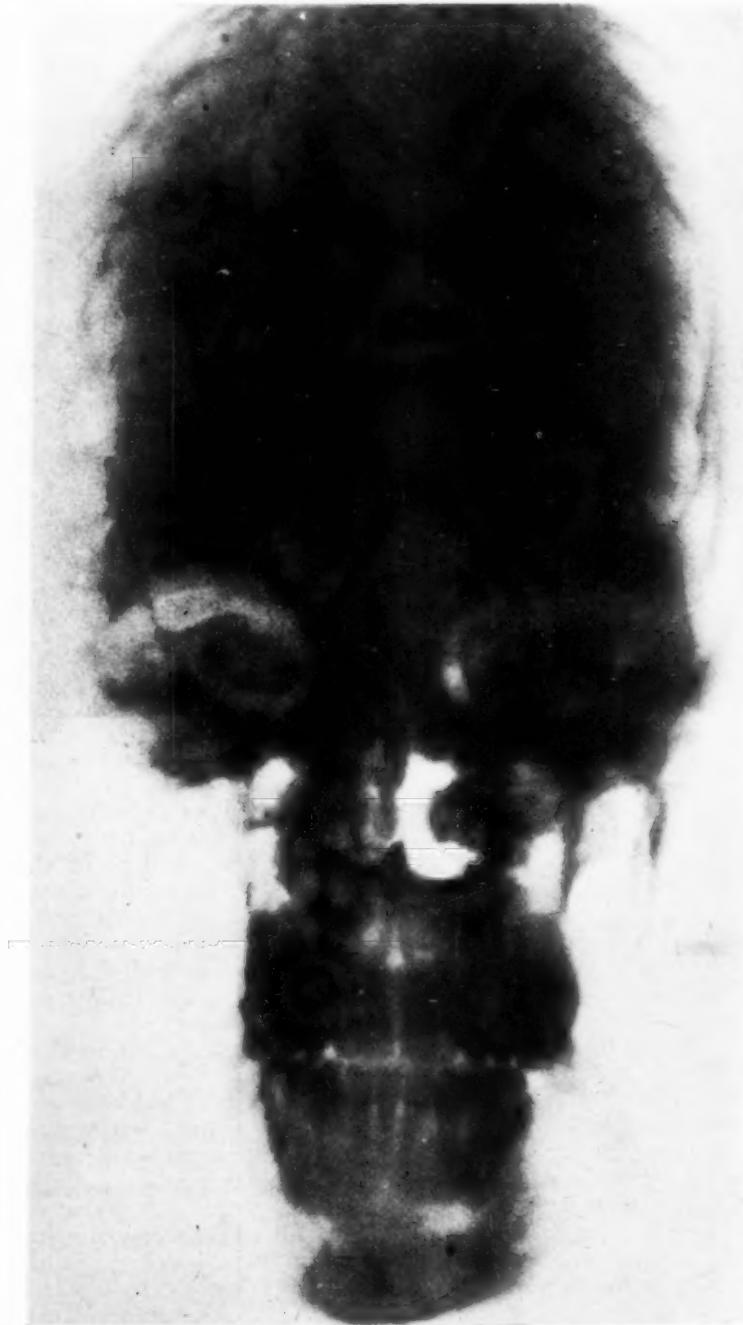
Case 2. Roentgenogram from the front. High dome shaped head; all sutures appear closed; sinuses well developed.
